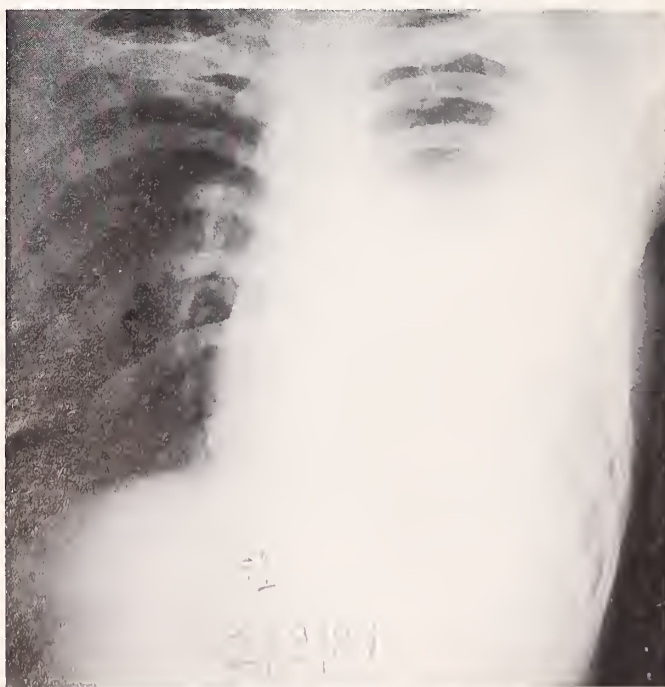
Initial chest roentgenogram with massive left pleural involvement.
